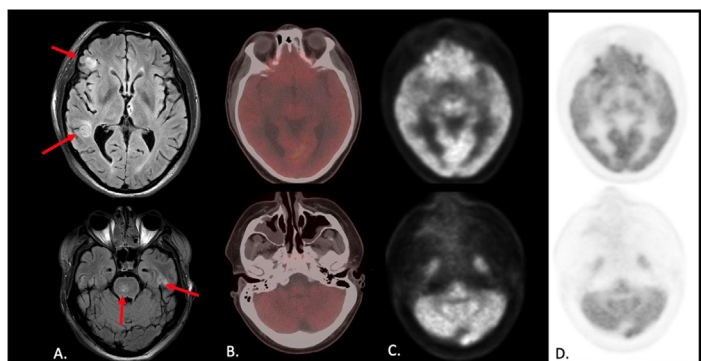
Column A. shows axial sections of a T2 FLAIR MRI sequence, with a few T2 hyperintense intracranial lesions (red arrows). Columns B, C, and D show axial sections of a post-treatment FDG PET-CT, which does not show FDG avidity corresponding to the lesions seen on MRI. .
